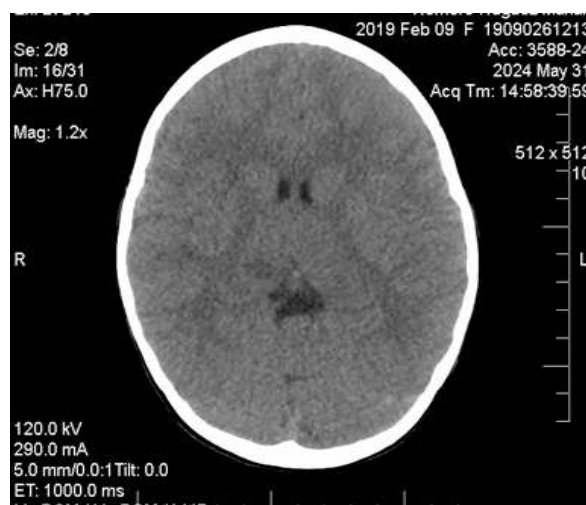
Simple CT scan of the skull showing signs of cerebral edema
